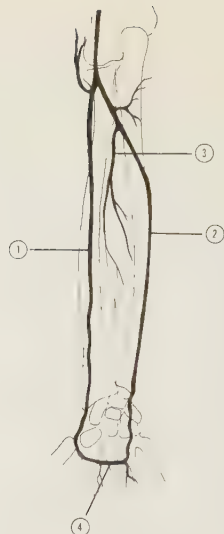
MAIN VEINS OF THE ARM, VOLAR ASPECT.
